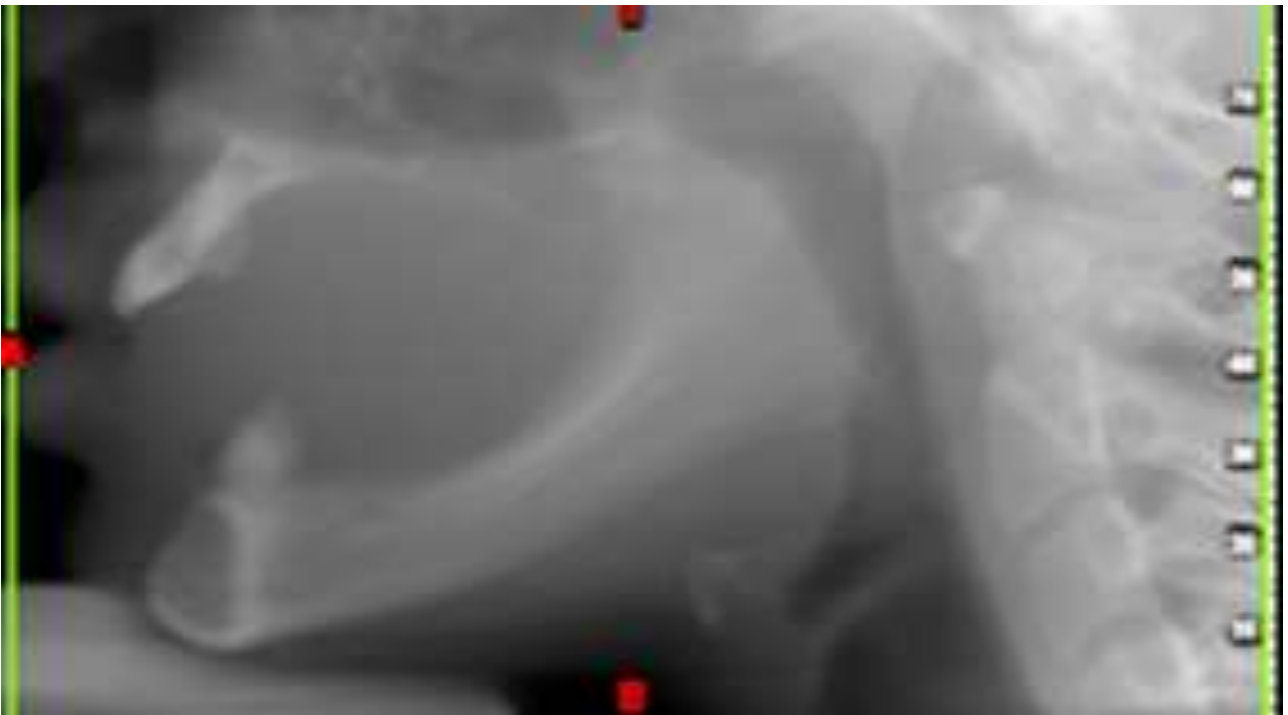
Lateral radiographic view
